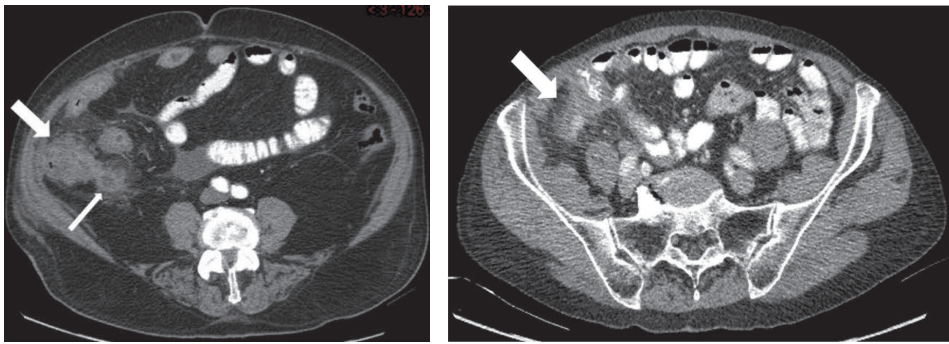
CT images of two appendiceal tumor patients with acute appendicitis. No obvious signs of any tumor, but wall thickening of cecum (thick arrow) and appendiceal lumen dilatation (narrow arrow).
